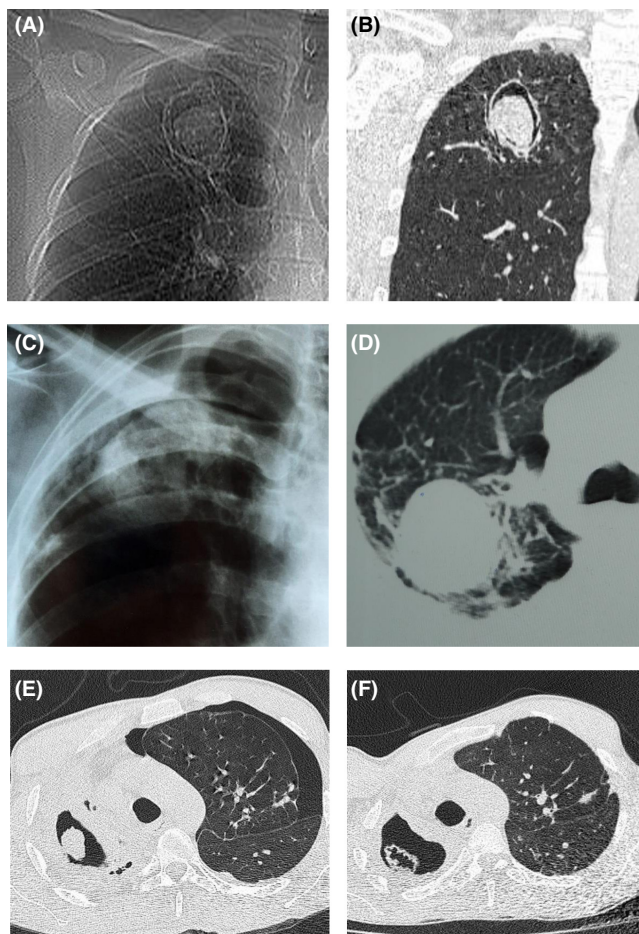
Chest images of three patients with aspergillosis. Patient no. 79: posteroanterior (PA) radiograph of the thorax (A) and high-resolution chest CT scan (B) showing a cavity with a fungus ball surrounded by an air crescent in the right upper lobe. Patient no.152: The PA chest radiograph (C) and high-resolution chest CT scan (D) show a mass without the typical air crescent signal. Patient no. 157: High-resolution chest CT scan (E) showing a cavity with fungal balls in the right apex at admission and 12 months after itraconazole therapy (F) showing that the disappearance of the fungal ball increased the size of the cavity and decreased pleural thickness
